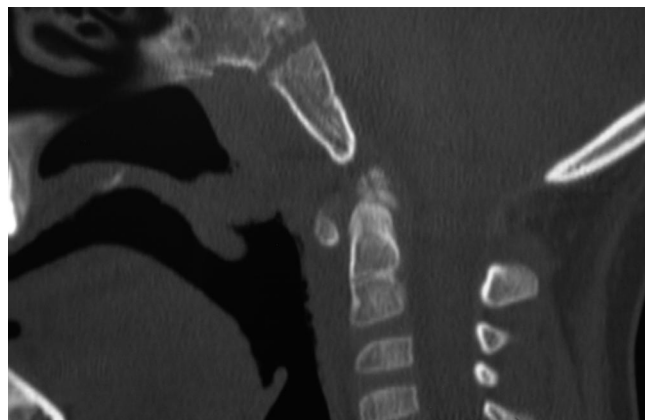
Postoperative computed tomographic scan (sagittal view) obtained after pharyngeal flap pharyngoplasty. Note that the base of the flap is positioned high on the posterior nasopharyngeal wall at the level of attempted velopharyngeal closure.
